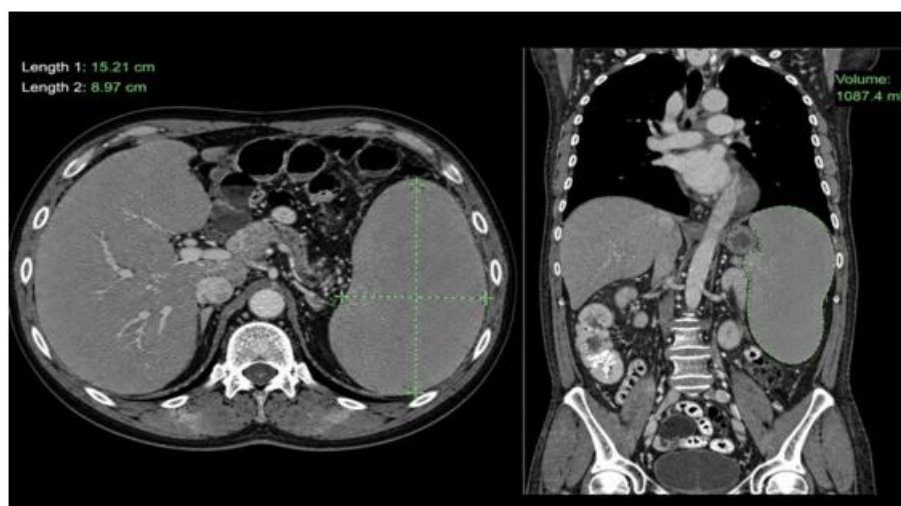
Axial contrast-enhanced CT image demonstrating splenic volume measurement using electronic calipers in a patient with splenomegaly and portal hypertension
